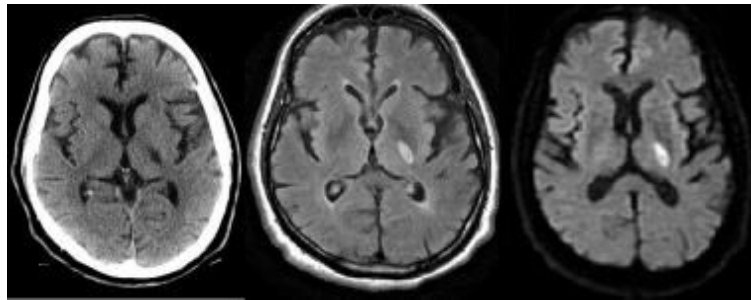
Lacunar stroke CT and MR images (Jauch, 2015).
